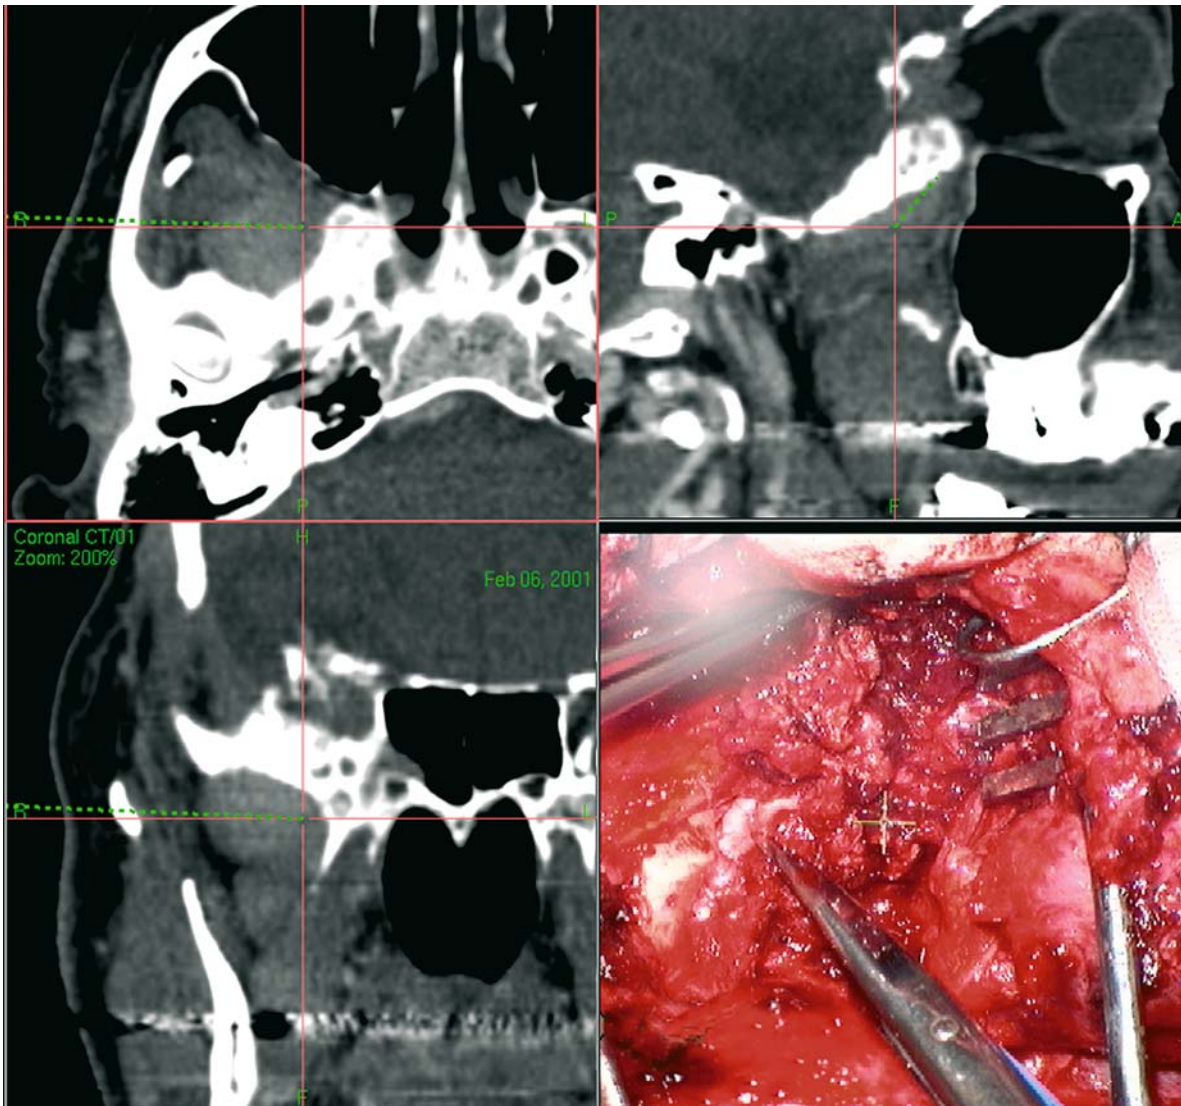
Navigation-assisted resection of meningioma. The intraoperative view of the operative field in the multiplanar display of the CT data set enables the surgeon to achieve
